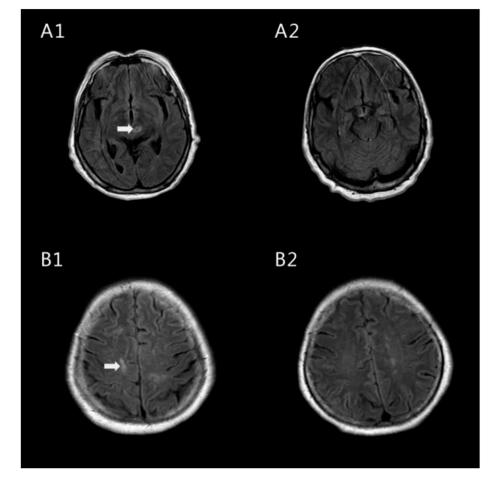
Flow alternating inversion recovery-magnetic resonance imaging of the female patient's brain before and after treatment. The arrows indicate the hyperintense signal that suggests multiple inflammatory foci in specific areas before treatment (A1, B1). They disappeared after treatment (A2, B2).
